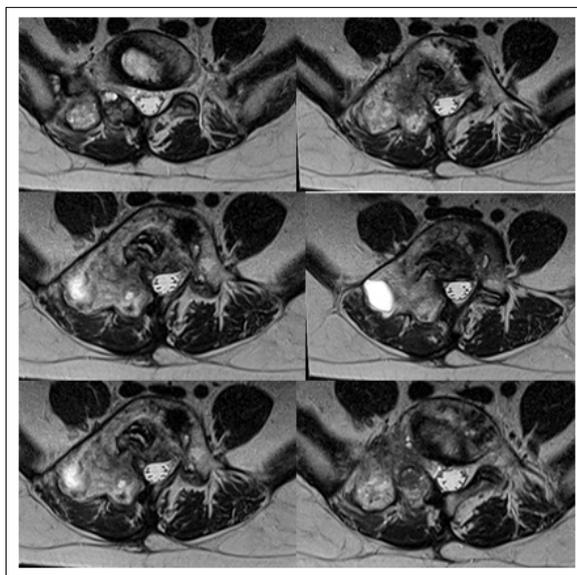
The Follow-Up MRI 3 Months after the Completion of IMRT
